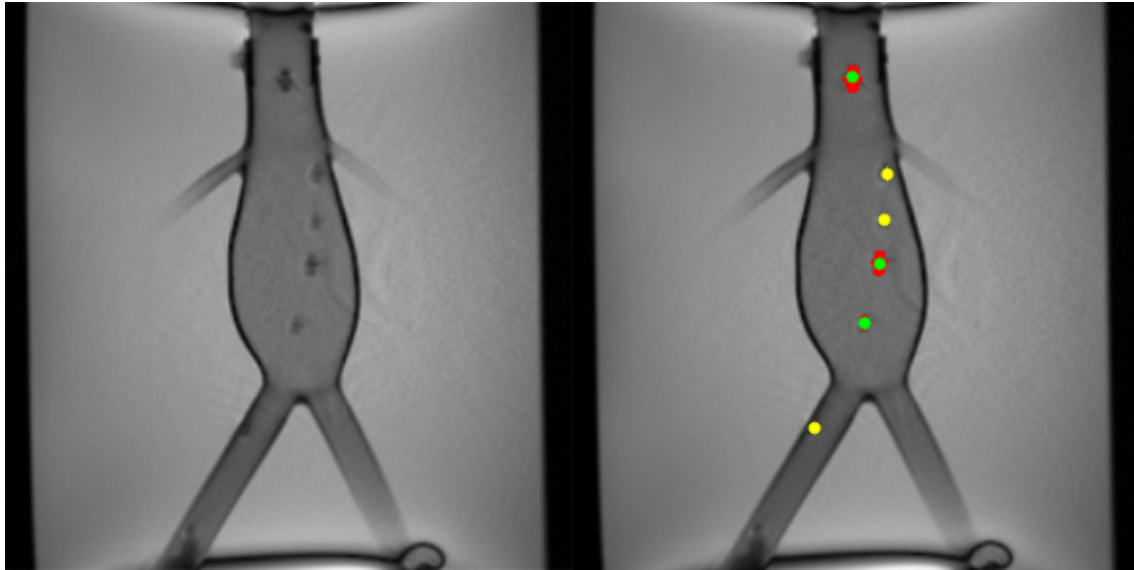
A frame with many missed detections caused by guidewire movement and the resulting loss of contrast in artefact signal. The left image shows the original MR image, while the right image has the evaluation script overlay.
